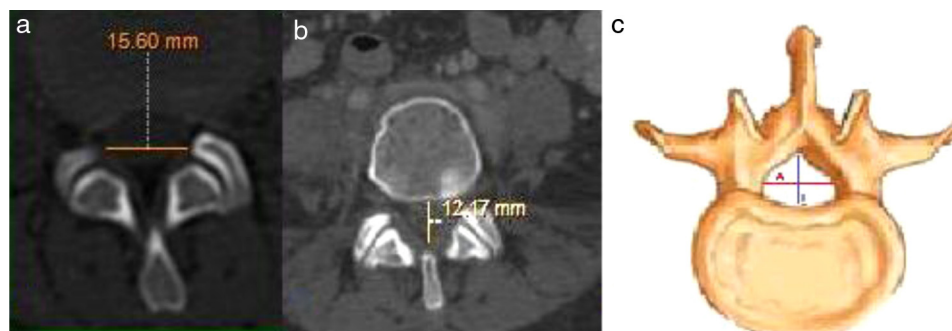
Methods to measure transverse (A) and antero-posterior, (B) diameter in CT images and bone image, (C) defining both the diameters.
